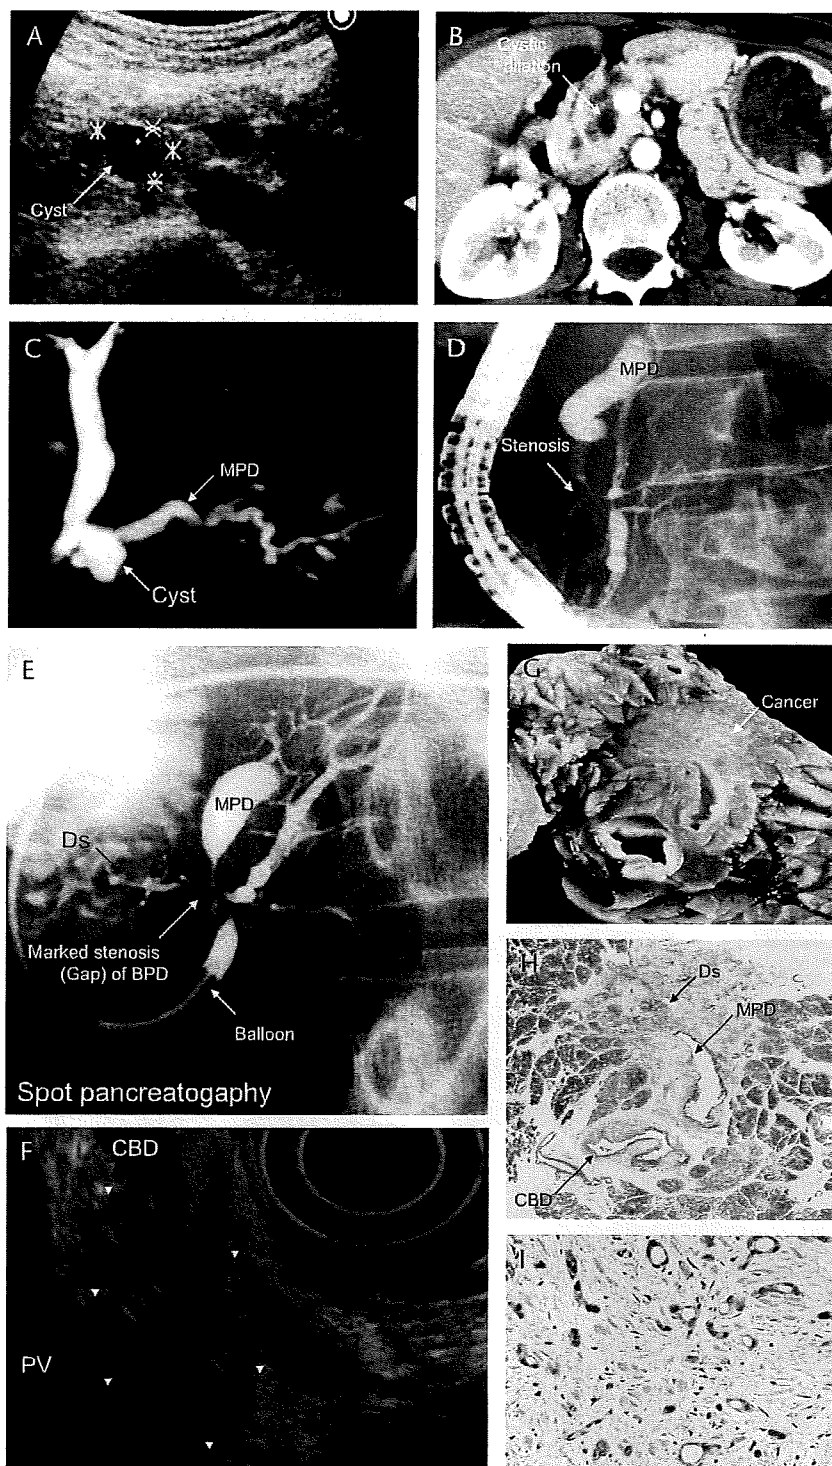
Case 3. A–D, Diagnosis of cancer was not obtained by US, CT, and MRCP. (A–C) Cystic dilatation of the pancreatic duct in the head of the pancreas (US, CT, and MRCP). (D) Smooth narrowing at the area of the confluence of the MPD and Santorini duct highly suggestive of carcinoma (ERP). E–I, Balloon spot pancreatography displayed findings characteristic of cancer. (E) Severe stenosis at the area of the junction between the MPD and Santorini duct. Marked stricture of the branch ducts showing gap (arrow) that is useful in differentiating cancer from chronic pancreatitis (balloon spot pancreatography). (F) An ill-defined hypoechoic mass with an irregular echogenicity (EUS). (G) A solid whitish mass in the head of the pancreas. (H and I) Poorly differentiated adenocarcinoma
